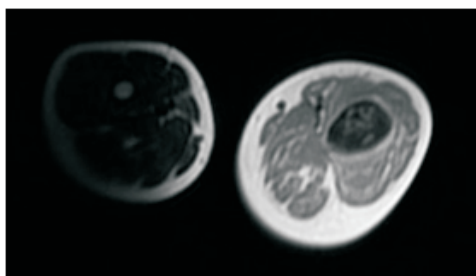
Axial T1 weighted MR image shows heterogeneously low signal intensity in femur.
